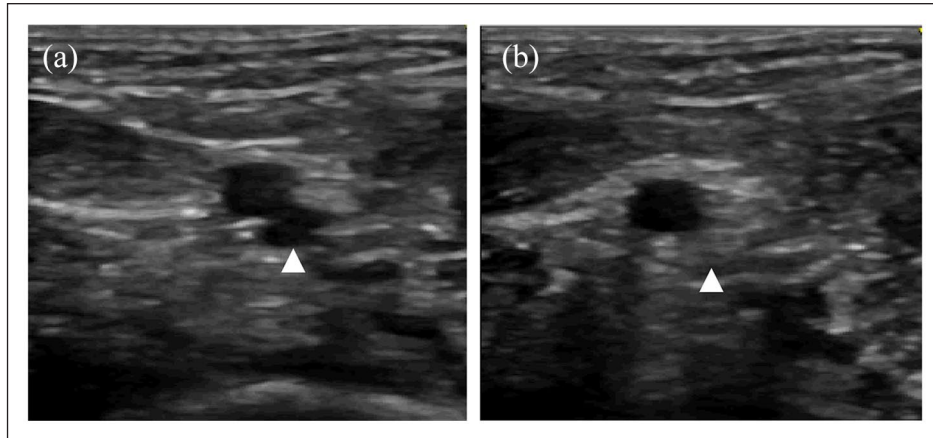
Representative image of a negative ultrasound assessment of a PIV performed by nursing during the study: (a) before normal saline flush and (b) during normal saline flush; white arrow: vein proximal to PIV.
